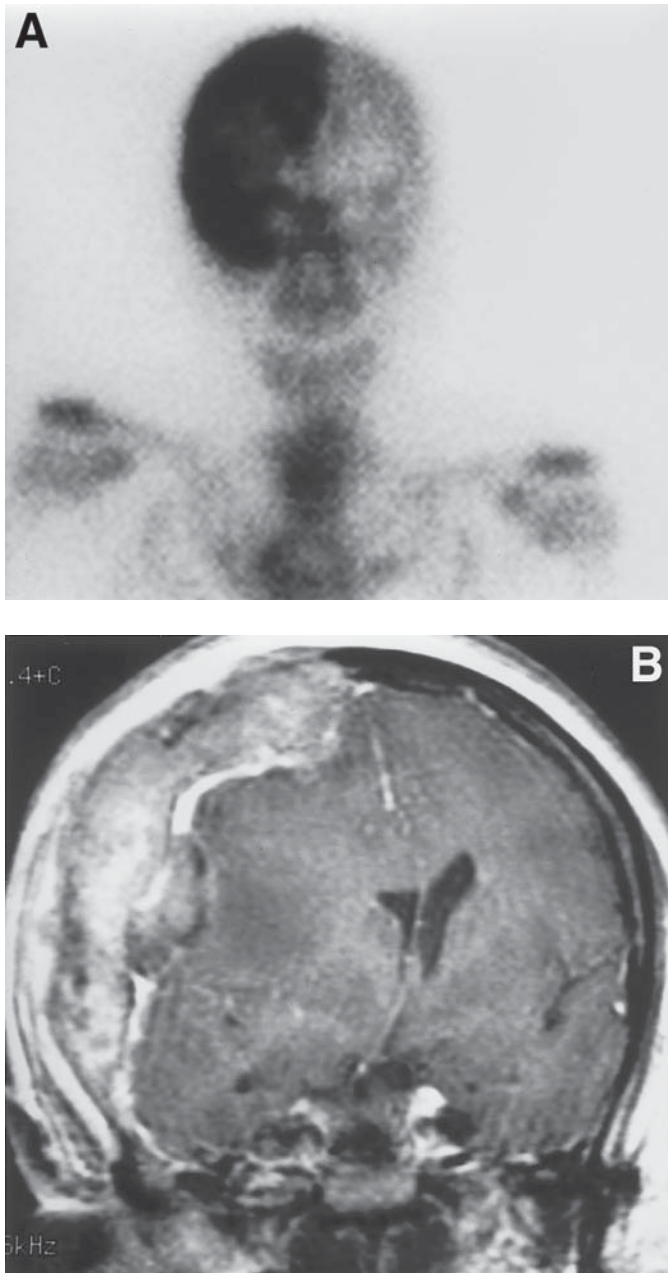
This 68-yr-old patient noted a “bulging” in the right scalp region and a firm breast mass for 8 mo. (A) Whole-body bone scintigraphy shows substantial radionuclide uptake in the right calvaria. (B) This breast cancer metastasis corresponds to the enhancing mass on MRI that is centered in the diploic space, but traverses the dura and arachnoid to invade the subjacent brain parenchyma and produces significant mass effect with subfalcine herniation.
